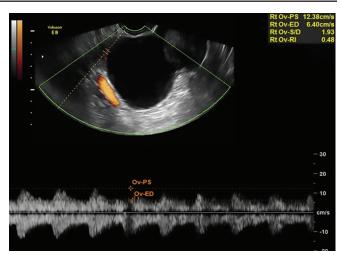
The same patient as in Figure 5. Note a well-delineated sonolucent cystic structure on the right ovary $(2.7 \times 2.5 \times 2.8 \text{ cm})$ with moderate vascular impedance (resistance index 0.48). Sonographic and Doppler findings are suggestive of an unruptured follicle
